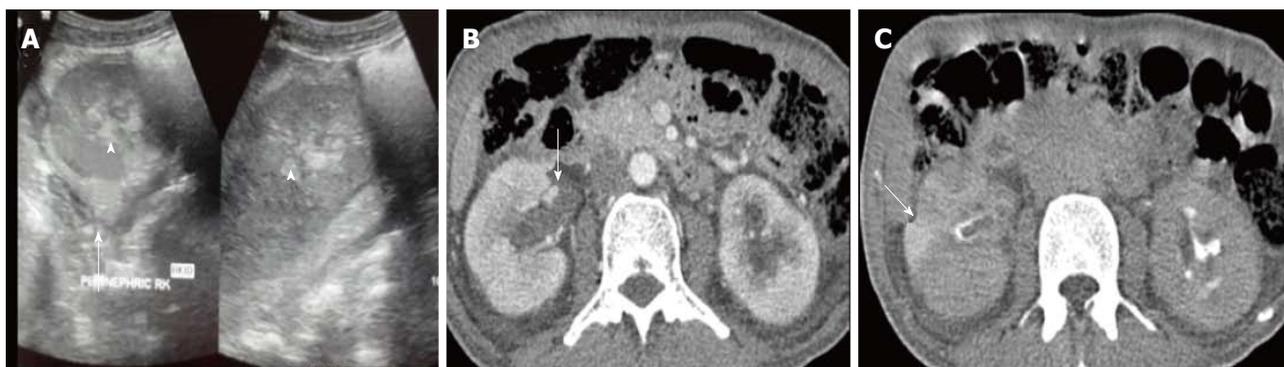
Acute pyelonephritis in a 40 years old male. A: US shows soft tissue in bilateral PCS (arrowhead) with increased echogenicity of perinephric fat (arrow); B: CECT nephrographic phase shows bilateral enlarged kidneys with heterogeneous enhancement. There is soft tissue thickening and abnormal enhancement of bilateral PCS and ureter (arrow); C: CECT delayed phase shows striated nephrogram (arrow) seen as linear bands of contrast extending from cortex to medulla. US: Ultrasonography; PCS: Pelvicalyceal system; CECT: Contrast-enhanced computed tomography.
